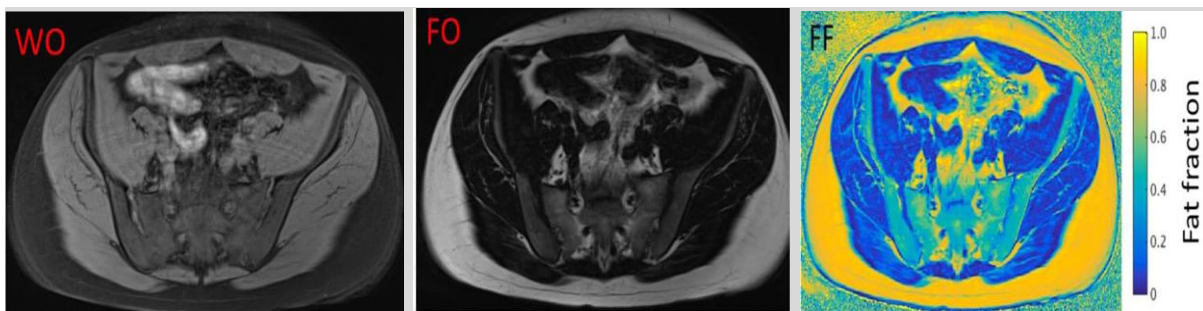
An example of MRI Dixon images and fat fraction map (FF%). Dixon sequence produces water-only (WO) and fat-only (FO) images and quantitative measurements of fat deposition (Bray et al. 2018).
